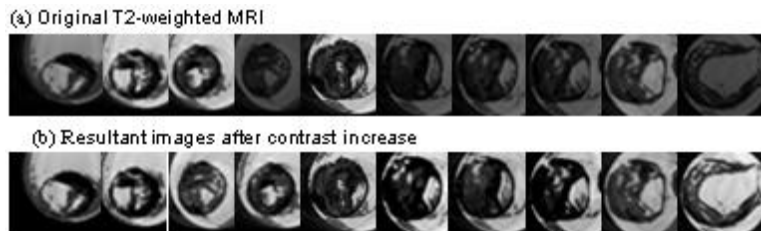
Pre-Processing results of selected slices from all 32 slices of *ex vivo* MR Images: (a) original T2-weighted MR images; (b) resultant images after contrast increase.
